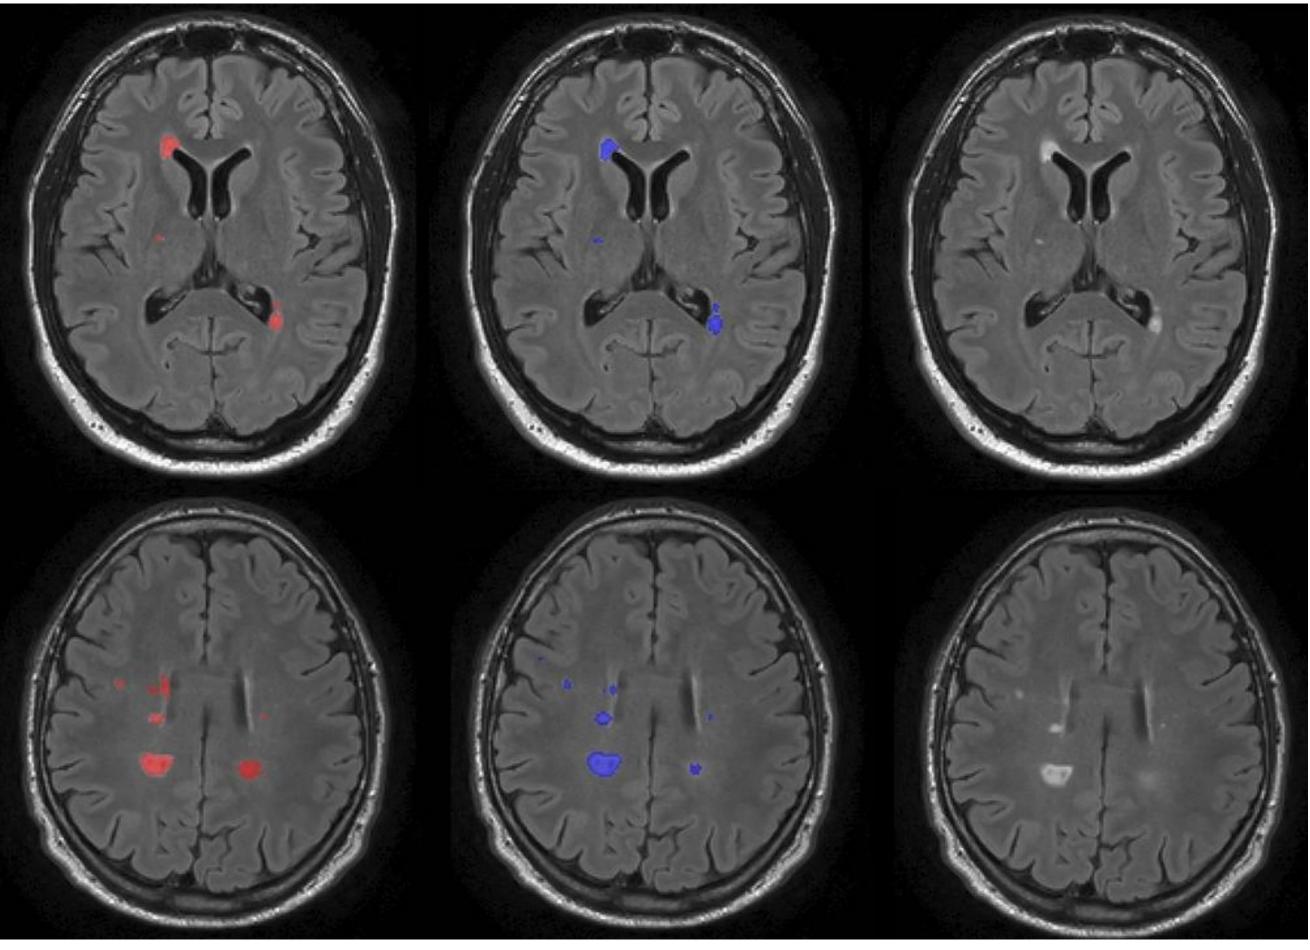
Examples of lesion segmentation for two different patients (in the two rows) performed by the proposed method (in red) compared to the gold standard (manual segmentation) (in blue). The corresponding FLAIR images are shown in the right column.
